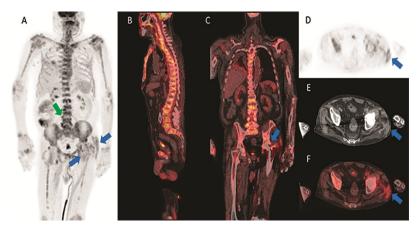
Fluorine-18-FDG PET/CT scan (A) MIP, (B) sagittal fusion, (C) coronal fusion (D) PET axial (E) axial CT and (F) axial fusion images. Diffusely increased ¹⁸F-FDG uptake in the whole skeleton with focal "hot" areas, most evident in the lumbar spine (green arrow), sternum and pelvis (SUVmax 11.5); increased ¹⁸F-FDG uptake can also be seen in periprosthetic area and in the subcutaneous area of the lateral left thigh, corresponding to the surgical wound (SUVmax 5.4) (blue arrows).
